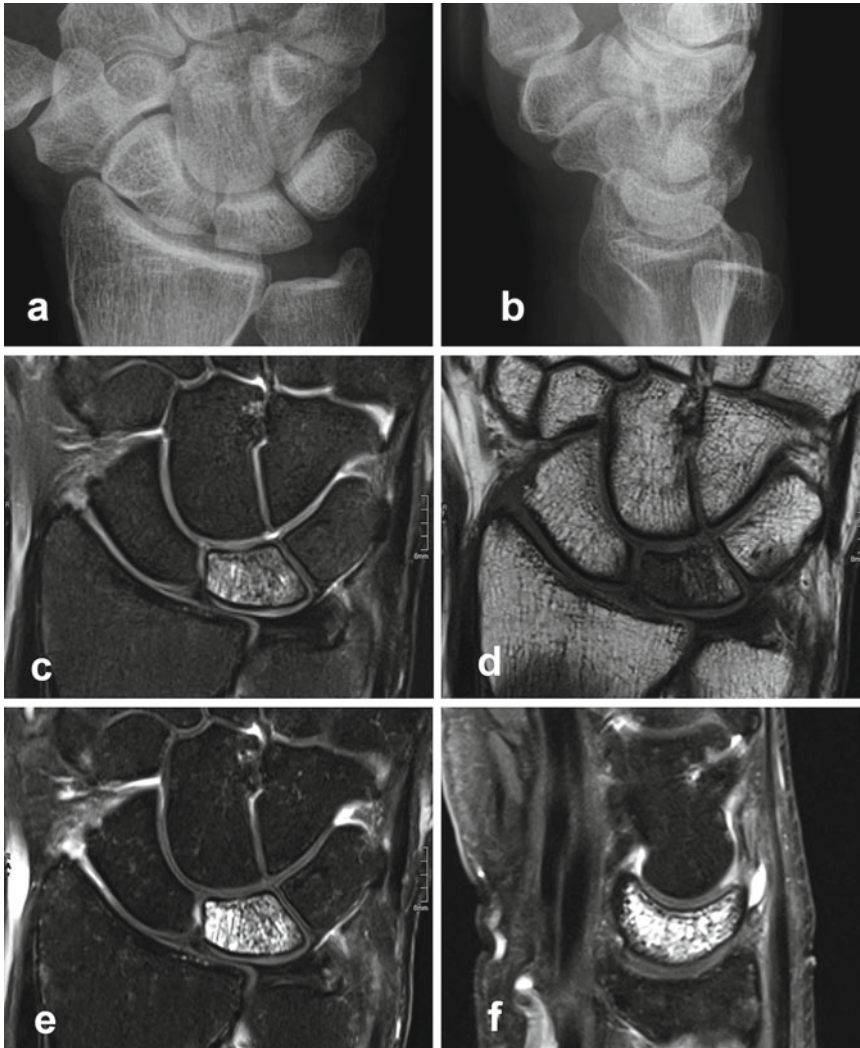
Ischemic lunate (MRI pattern A) in stage I of Kienböck's disease. Viability is maintained in edematous bone marrow of the lunate. 34-year-old male suffering from spontaneous onset of pain without previous wrist injury or overuse. (a, b) Dorsopalmar and lateral radiographs are normal and not suspicious of Kienböck's disease. Negative ulnar variance. (c) Territorial bone-marrow
